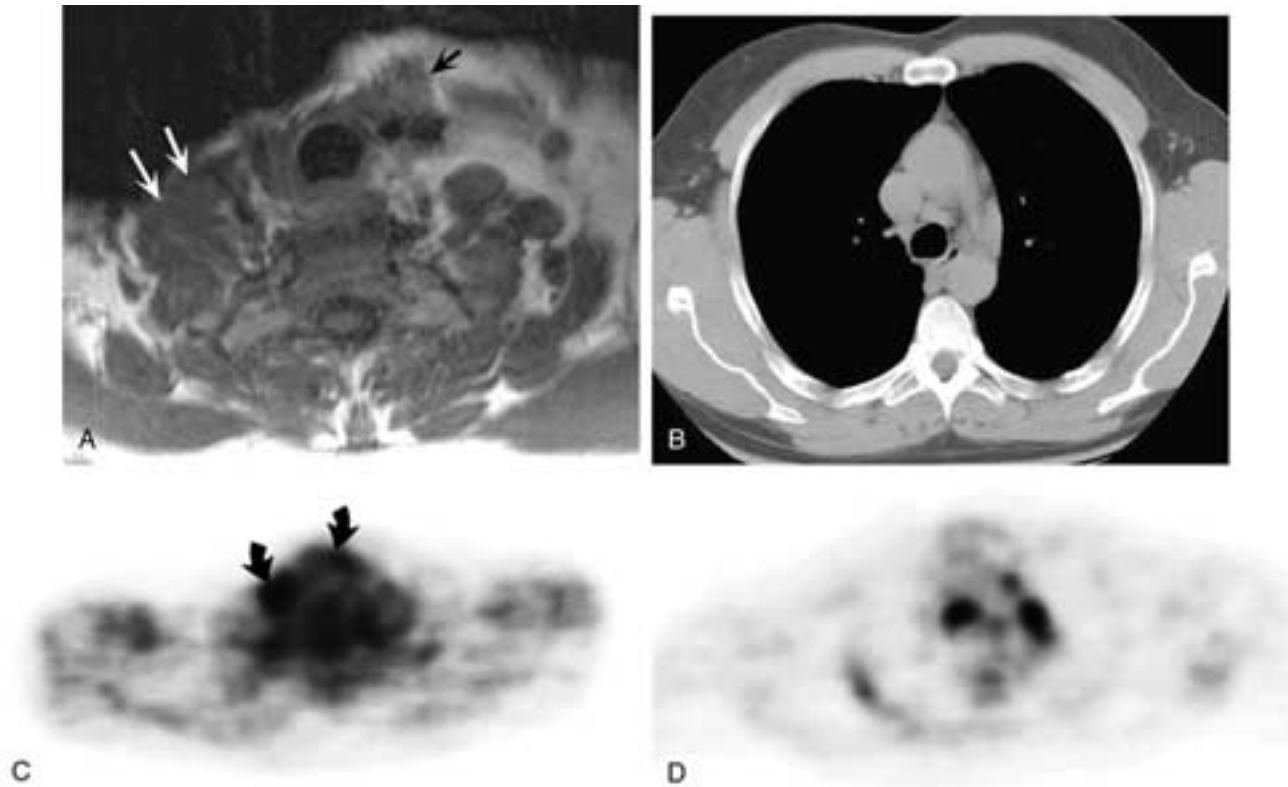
A 49-year-old man underwent total thyroidectomy and right neck dissection for poorly differentiated papillary carcinoma of the thyroid. He was subsequently treated with radioiodine, and follow-up whole body ^{131}I scans were negative. The patient was reimaged because of rising thyroglobulin levels and concern for recurrent disease. A, An axial T1-weighted image from an MR scan of the neck demonstrates soft tissue in the right anterior low neck (*white arrows*), but it is unclear if this is scarring and fibrosis related to prior neck dissection or residual or recurrent tumor. Focal soft tissue in the left anterior neck (*black arrow*) may similarly represent either treatment effects or tumor. B, An axial image from a noncontrast CT scan of the chest demonstrates pretracheal and anteroposterior window lymph nodes, none of which are clearly pathologic. C, An FDG PET image through the low neck confirms focal tracer accumulation in both sites in the neck that were suspicious on MR imaging (*arrows*). D, Multiple mediastinal nodes also accumulate tracer. Further neck surgery and mediastinoscopy confirmed the presence of thyroid cancer at these sites.
